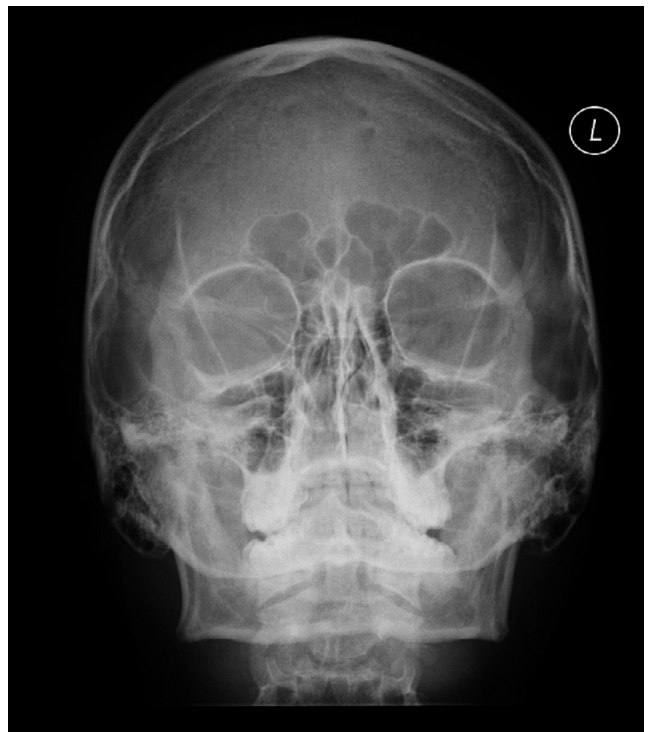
X-ray control of nasal sinuses after removal of the foreign body
